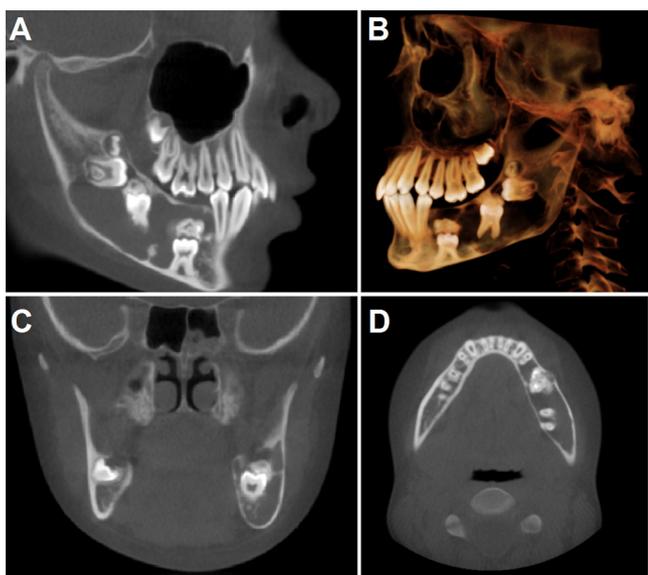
Cone beam computed tomography (CBCT) imaging. (A) Sagittal view depicting a predominantly radiolucent mixed-density lesion in the mandible with multiple radiopaque entities of tooth-like morphology and density. (B) 3D reconstruction showing retained and displaced deciduous second molar and displaced permanent first and second molars. (C) Coronal view depicting an impacted tooth with a radiopaque entity of tooth-like density and morphology superior to it. (D) Axial view showing mild bucco-lingual enlargement and thinned borders. *Color online only*.
